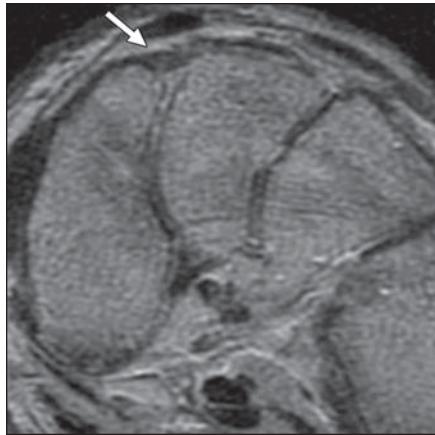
Dorsal intercuneiform ligament coronal proton density MR image after injection of intraarticular gadolinium solution shows dorsal intercuneiform ligament between C1 and C2 (arrow).
